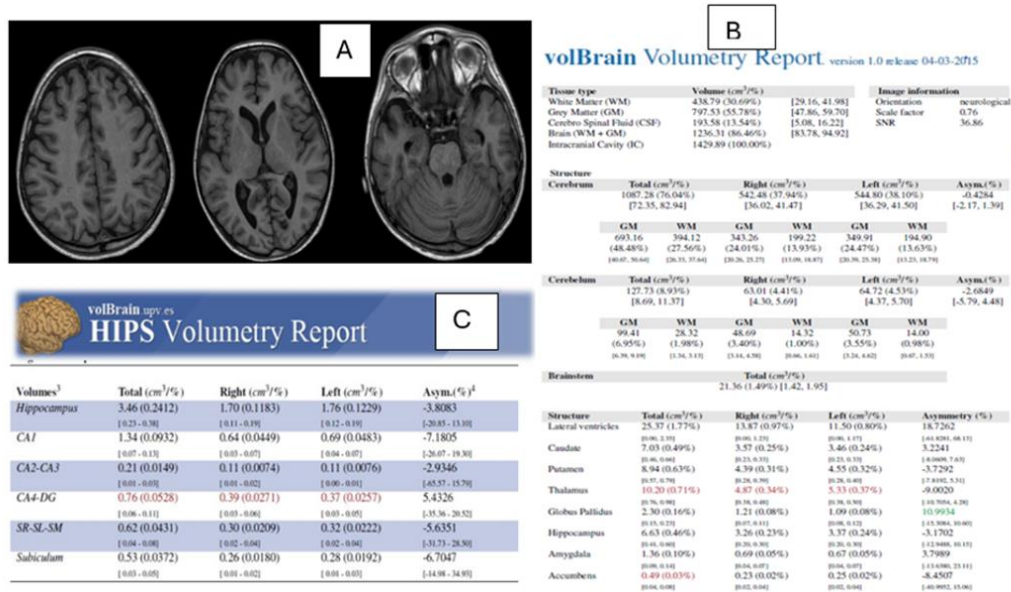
A 12-year-old male patient with generalized tonic-clonic seizures. A. The 3D axial MRI of the brain shows no structural abnormalities or abnormal signals. B. MRI volumetry indicates a decrease in the volume of the right and left thalamus and the right accumbens volumes. C. MRI volumetry indicates a decrease in the volume of right and left CA4-DG segments.
